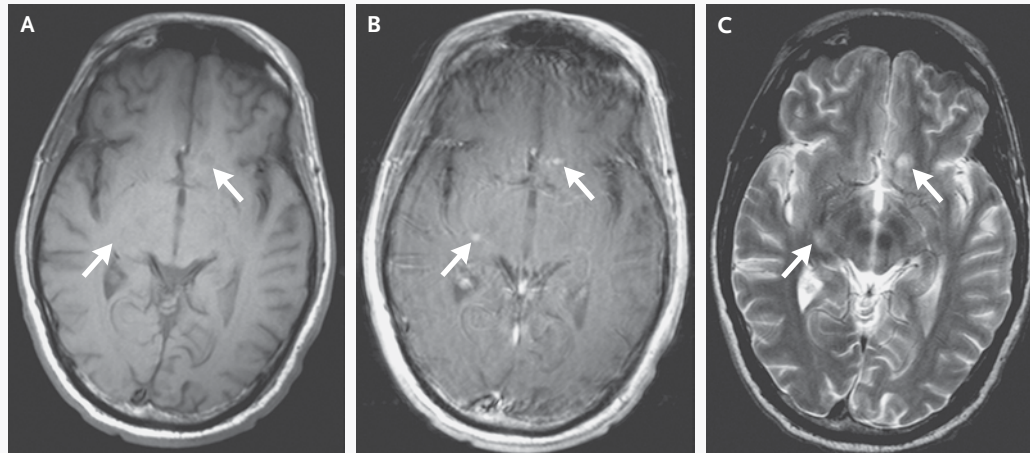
MRI Scans of the Brain.
